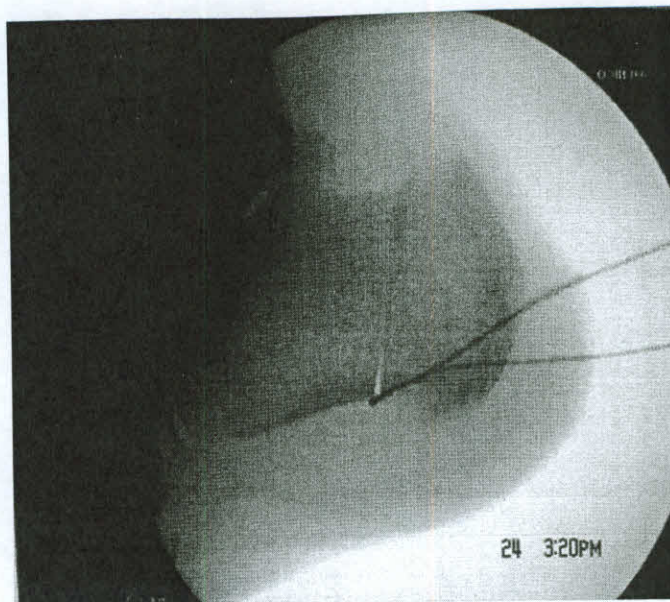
Intraoperative lateral radiographic view demonstrating percutaneous calcaneal displacement osteotomy after completion of the osteotomy.
